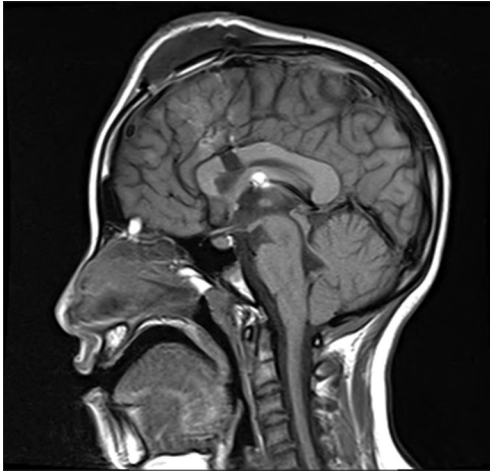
Magnetic resonance imaging of the brain showing evidence of an 8 mm incision in the anterior part of the body of the corpus callosum.
